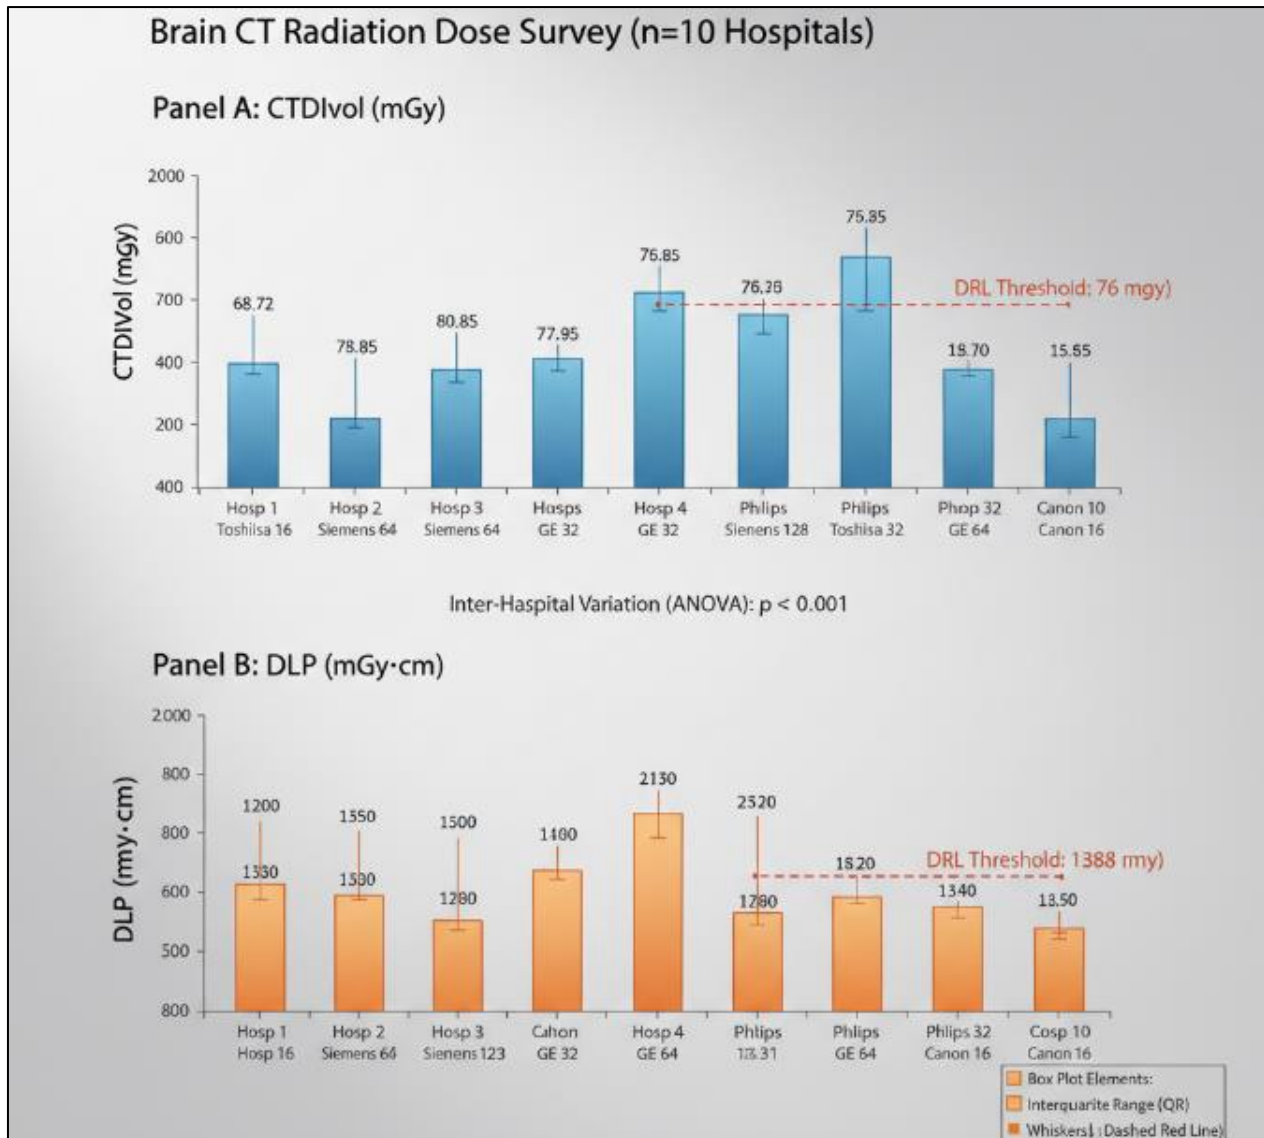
Abbreviations: CTDIvol, Volume CT Dose Index; DLP, Dose-Length Product; DRL, Diagnostic Reference Level; IAEA, International Atomic Energy Agency; UAE, United Arab Emirates; UK, United Kingdom; CI, Confidence Interval.
